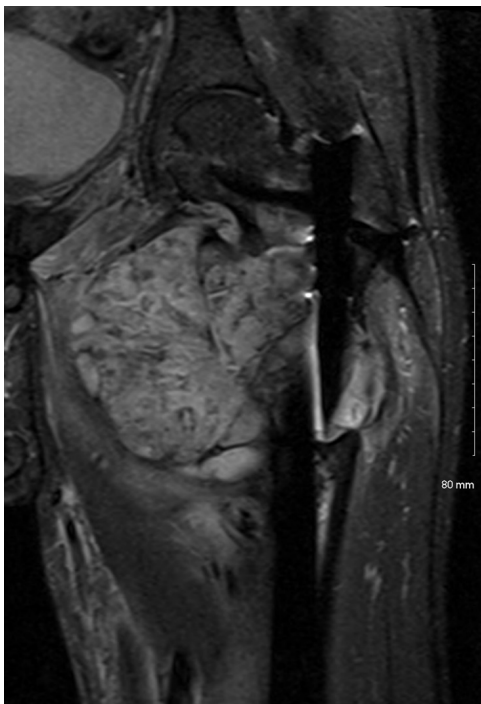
MRI (fat suppressed) of the left proximal femur, coronal
